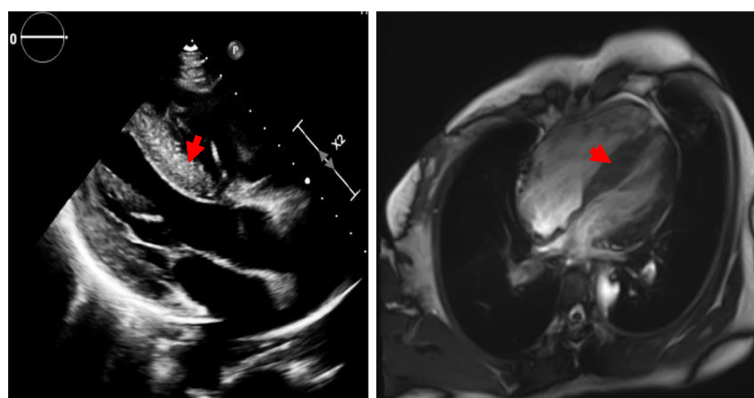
Thick interventricular septum (red arrow) in echocardiography (A) and MRI (B)
